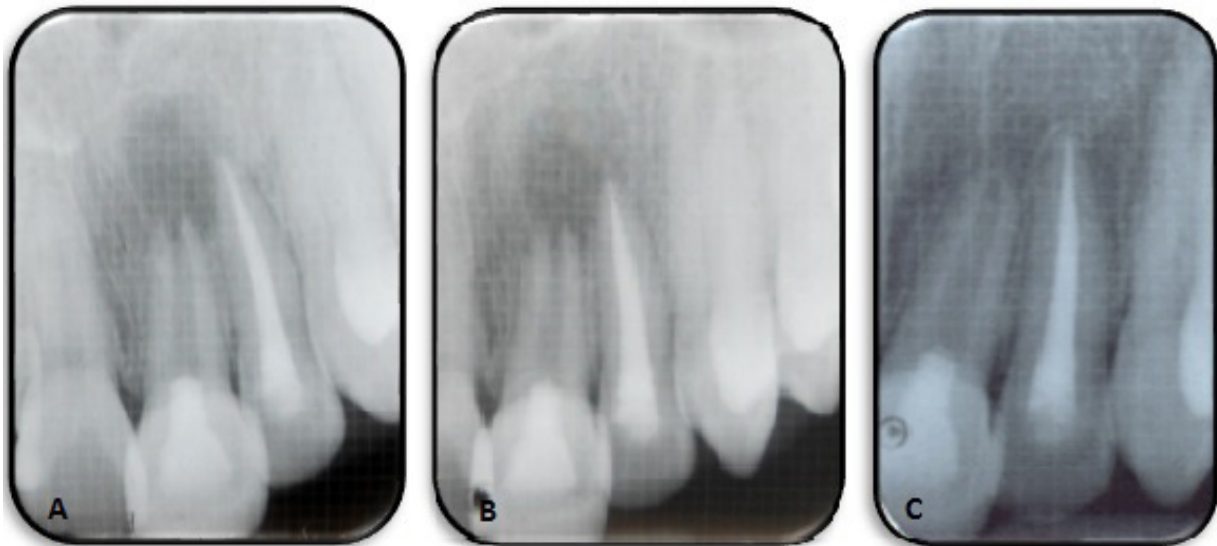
Follow up radiographs showing gradual regression of periapical radiolucency at (A) 1 week, (B) 3 months, (C) 12 months. Complete resolution of periapical radiolucency, root elongation and apex closure are evident.
